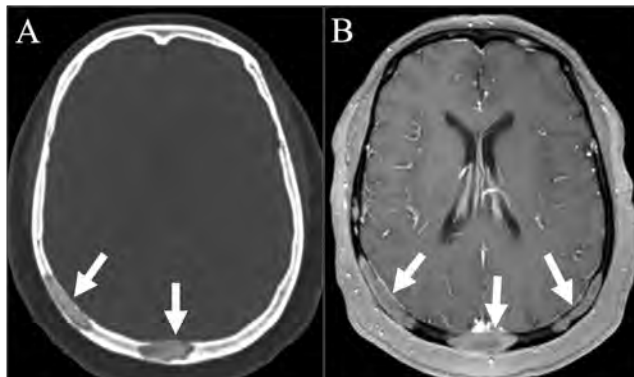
Pathologically proven calvarial bone involvement of sarcoidosis in a 60-year-old female. (A) Axial CT image shows slightly expansile, mixed predominantly lytic calvarial lesions (arrows) with a lace-like internal pattern of calcification. (B) Axial post-contrast T1WI demonstrates homogeneous enhancement of the lesions with underlying smooth pachymeningeal thickening and enhancement (arrows).
